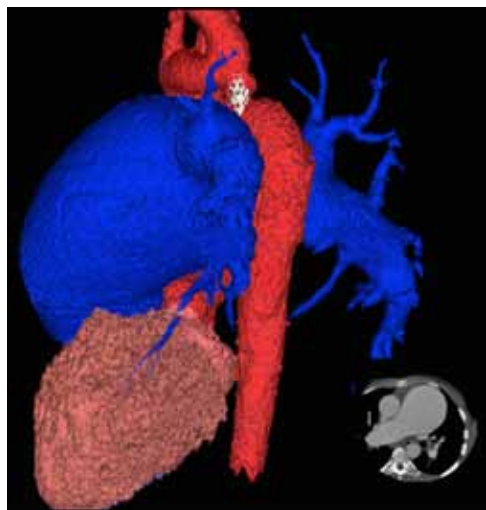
CT 3D reconstruction demonstrating aortic coarctation with stent placement (white) and prominent aortic dilatation distal to the coarctation.
